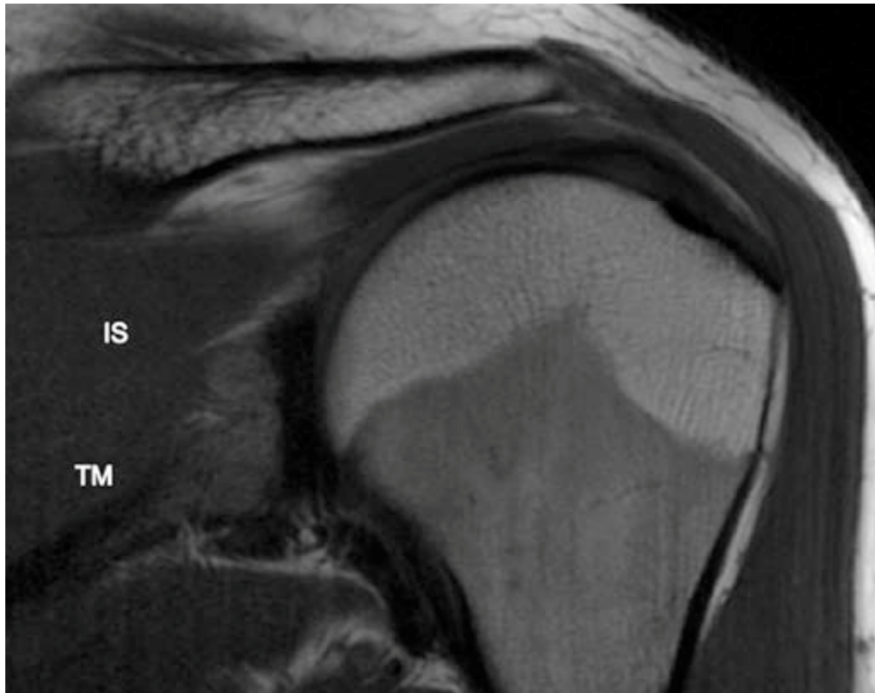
On this oblique coronal T1-weighted MRI picture, the normal infraspinatus muscle and tendon (IS) as well as the teres minor muscle (TM) lies under the scapular spine. (2)
